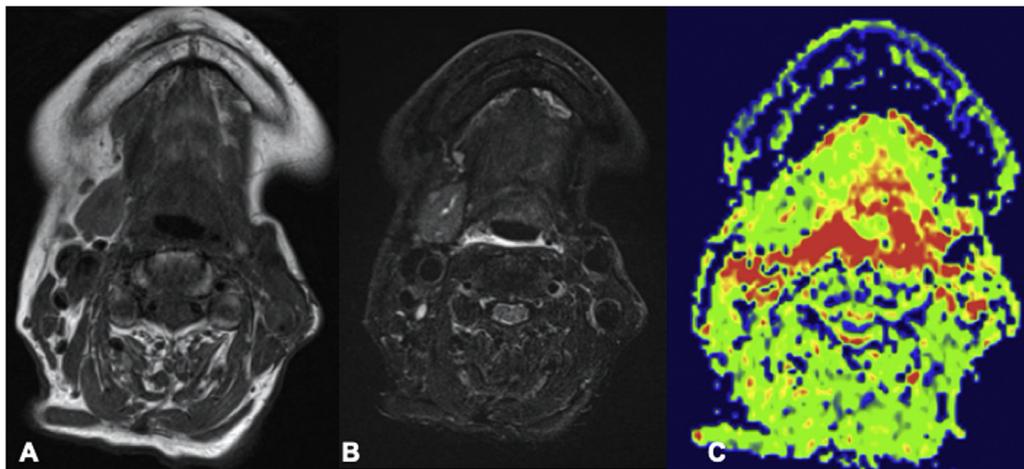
A 87-year-old female patient who had undergone resection of a malignant neoplasm in the maxillary sinus on the right side. (A) T1-weighted axial slices. (B) T2-weighted short tau inversion recovery (STIR) axial slices. (C) Its correspondent apparent diffusion coefficient (ADC) map.
